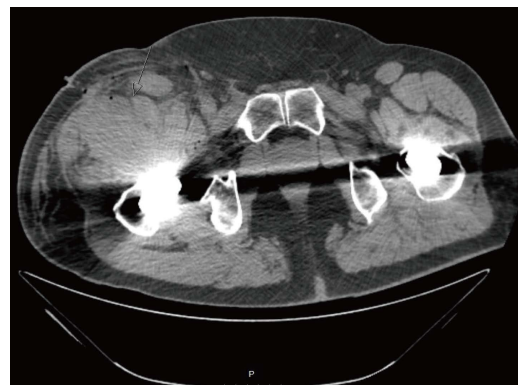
Transverse plane computed tomography scan showing a hematoma ventrally in the anterior compartment.
